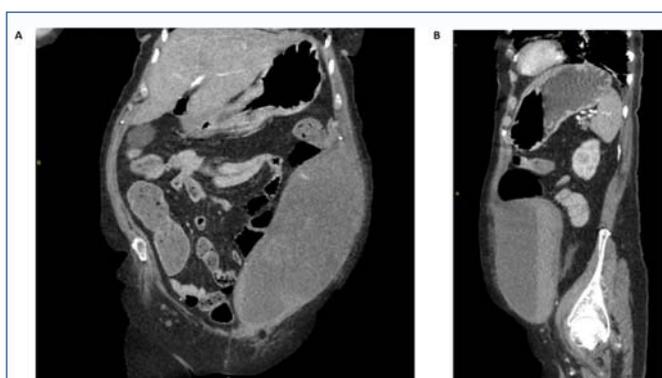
Contrast abdominal and pelvis CT A. coronal and B sagittal views demonstrating left anterolateral massive hematoma well contained in the left rectal sheath anteriorly in the inferior epigastric artery territory.
